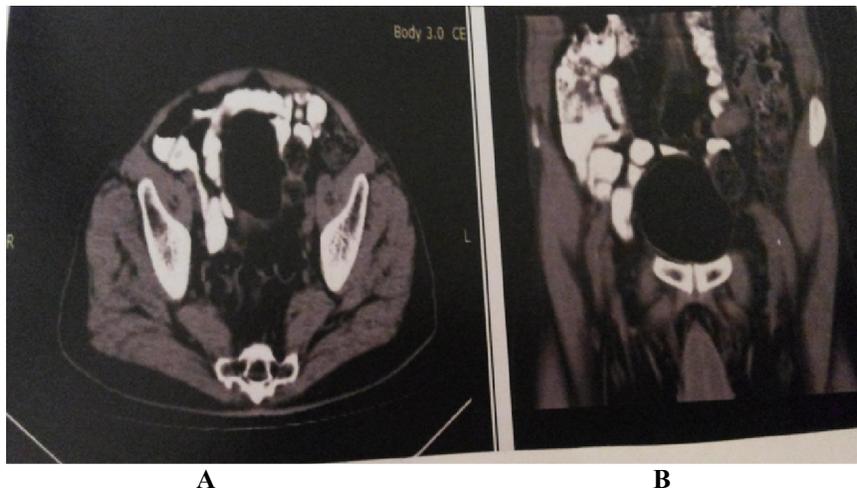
A&B: Axial and coronal reconstruction CT images revealed no mass lesion detected at different levels.
